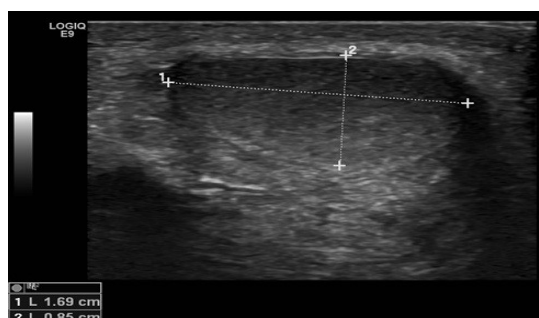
Longitudinal sonographic image of the structure in the right labia again demonstrates homogeneous internal echoes with an appearance and shape typical of a testicle. Through transmission, which would be typical of a cyst, is not present.
